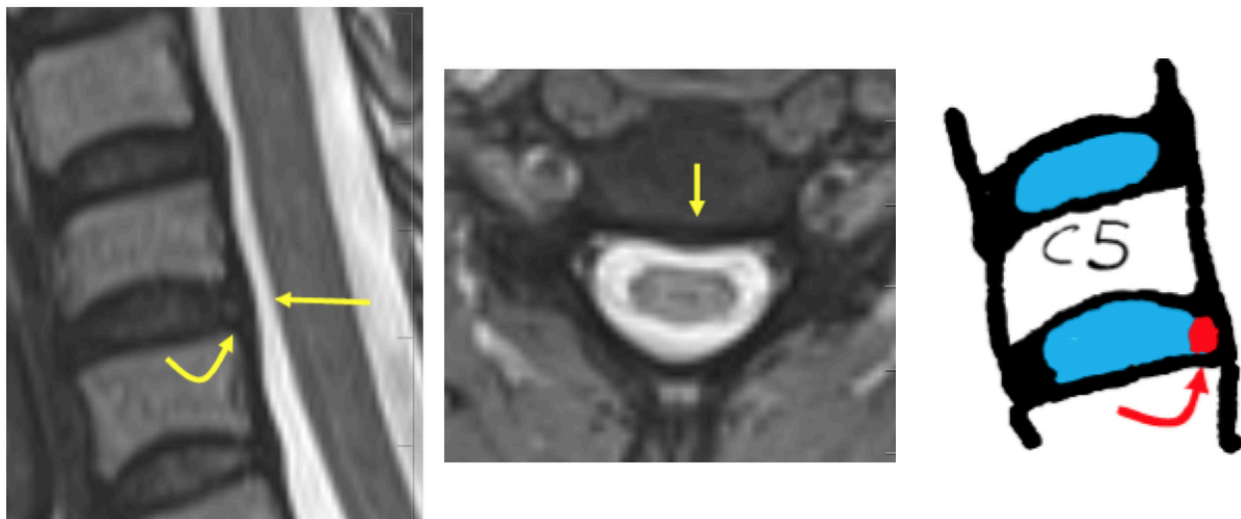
Median protrusion at level C5-C6. Axial and sagittal T2-weighted images.
